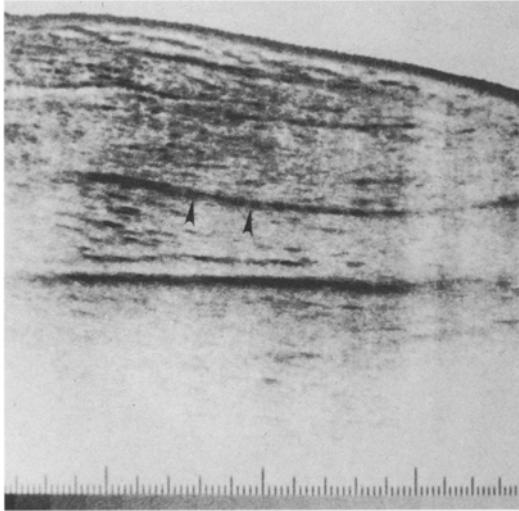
Normal follow-up ultrasonography of the right thigh. The posterior aspect of thigh is shown by double arrowheads
